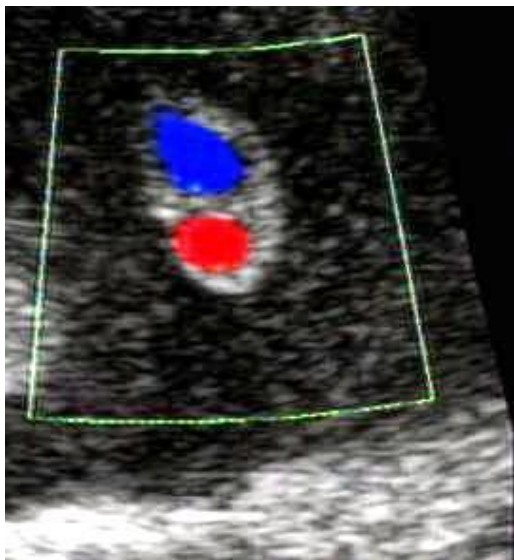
Colour Doppler findings reveal single umbilical artery.
